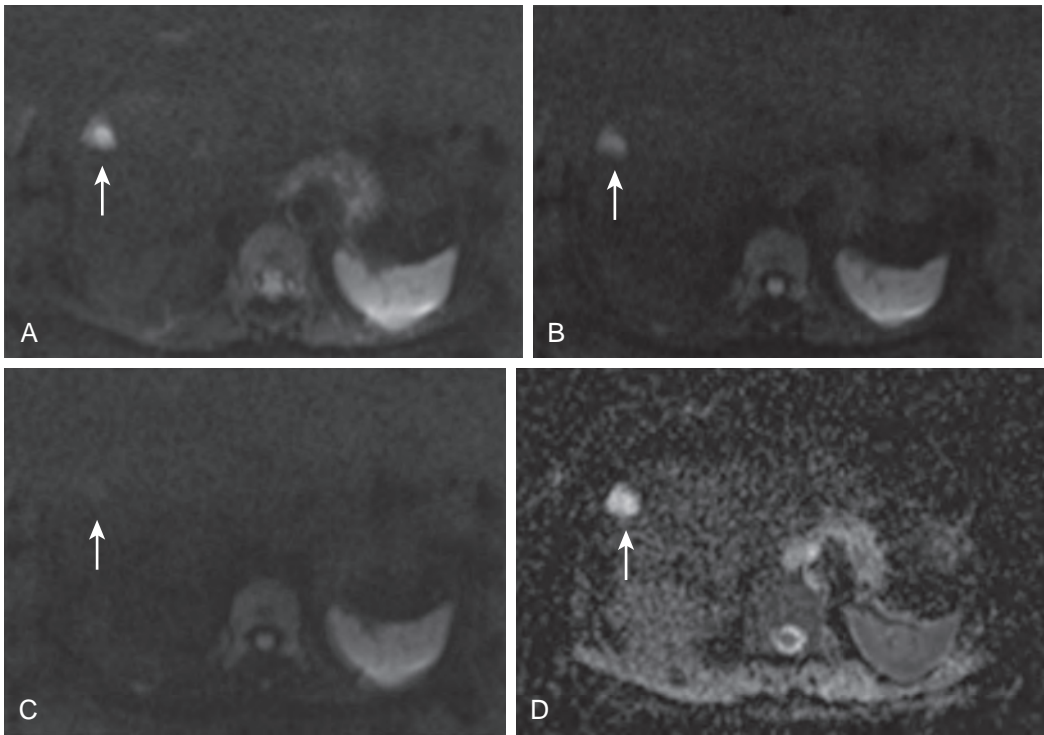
Simple cyst: diffusion-weighted MRI features with different b values. A simple cyst in the right lobe of the liver (arrow). The cyst is markedly hyperintense on the diffusion-weighted image with a b value of 50 (A). With increasing b values (B and C, 400 and 800, respectively), the cyst loses signal intensity. It has a high ADC value (D).
